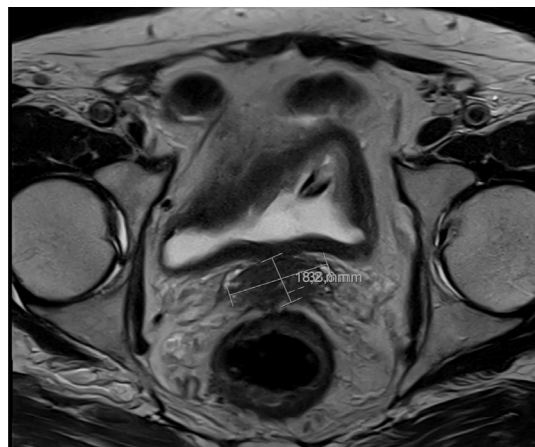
Post-treatment pelvic magnetic resonance imaging (MRI) obtained before radiotherapy demonstrating marked regression of the prostatic mass following treatment.
